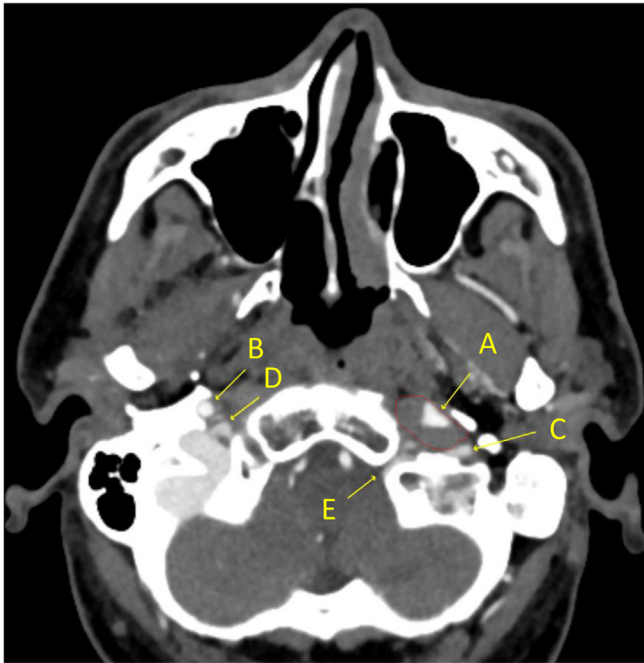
CTA at the time presentation: Source image at the level of the skull base demonstrates deformity of the left ICA lumen (A) which is partially encased by soft tissue density material (red outline) consistent with arterial dissection. Partial effacement of the internal jugular vein (C) just below the jugular bulb. The close relationship of the dissection to the left hypoglossal canal (E) is also demonstrated. Normal contralateral right ICA (B) and jugular bulb (D).
